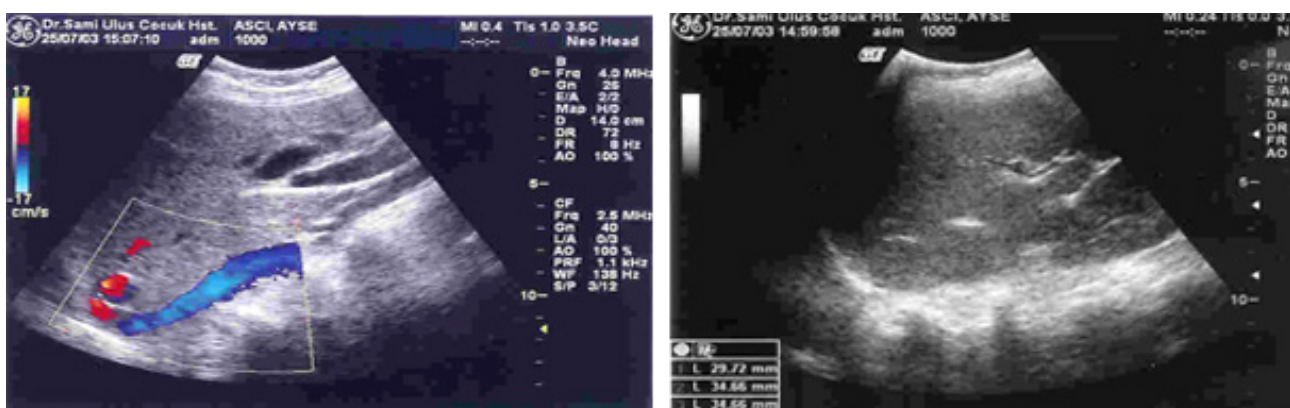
Ultrasonography revealed the dilatation of the bile ducts
